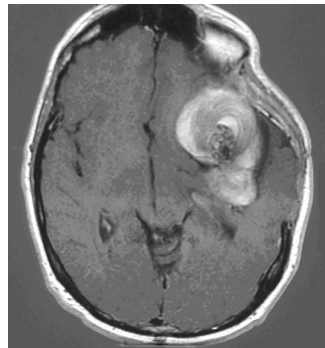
Axial T1-weighted magnetic resonance imaging scan of a patient with a giant fusiform partially thrombosed aneurysm of the left middle cerebral artery. The lumen of the artery (central flow void) is surrounded with layers of clot in a laminar fashion. The tendency of giant aneurysms to thrombose is a major difficulty in the stability of endovascular embolization of these lesions with high incidence of coil compaction into the wall thrombus.
